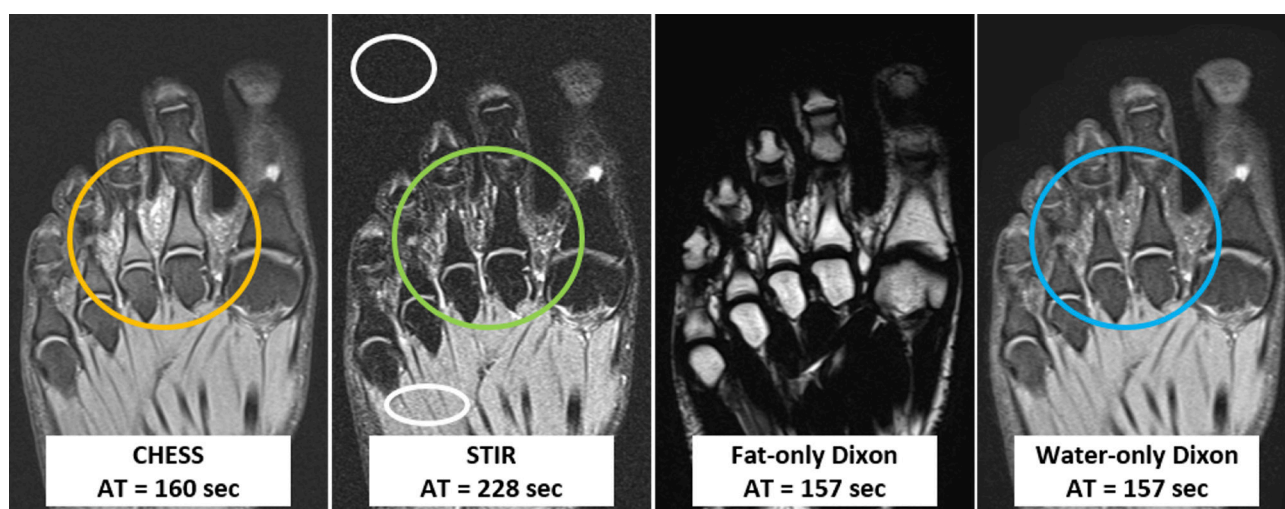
MR images of the forefoot in a 32-year-old man demonstrate the potential utility of the Dixon FSE sequence in the setting of forefoot infection. The typical pattern of failed FS in the marrow and soft tissues about the second and third toes on the CHESS sequence is demonstrated (gold oval). Appropriate FS is demonstrated in these regions on STIR (green oval) and water-only Dixon (blue oval). Note decreased SNR of STIR relative to the CHESS and water-only Dixon – decreased SNR is manifested by a grainy appearance of the muscles and air about the foot (white ovals). A fat-only Dixon sequence is also demonstrated which could provide additional diagnostic information. AT = acquisition time.
